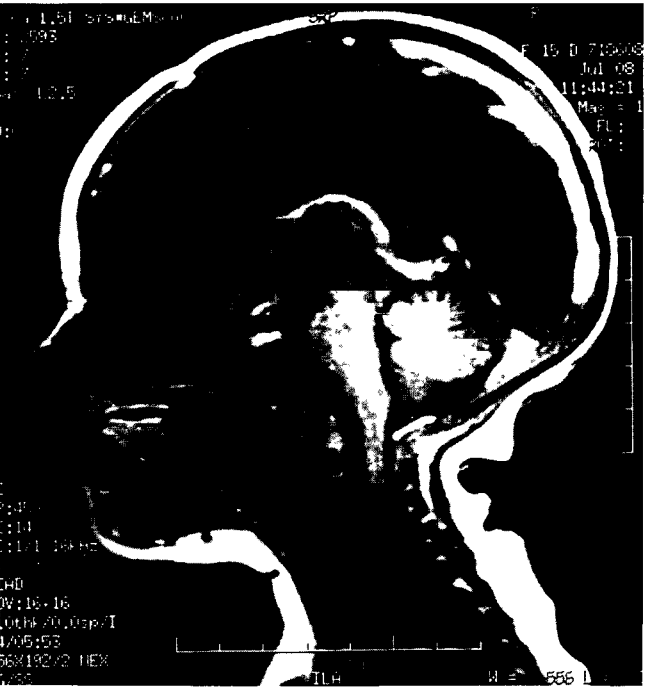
Midline sagittal T₁-weighted contrast-enhanced MRI shows extensive thrombosis of the superficial and deep venous system in a newborn with factor V Leiden gene mutation.
